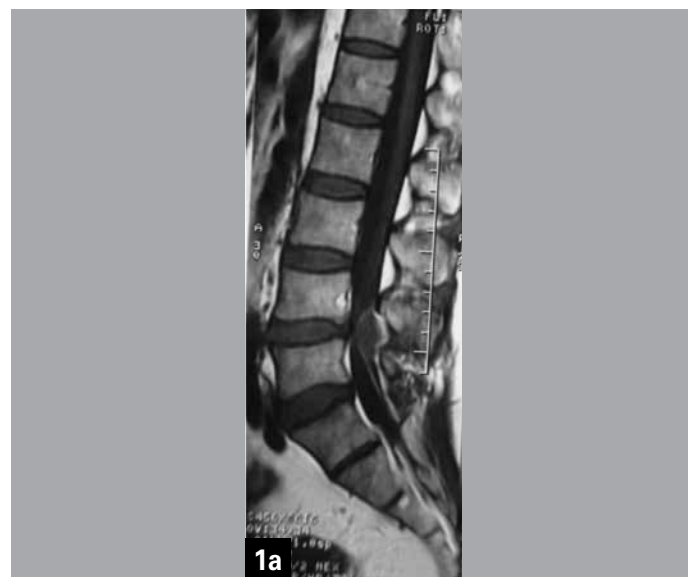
T1-weighted image showing a posteriorly located mass at the level of L3- L4- it is isointense relative to intervertebral disc. (L5 is sacralized)
